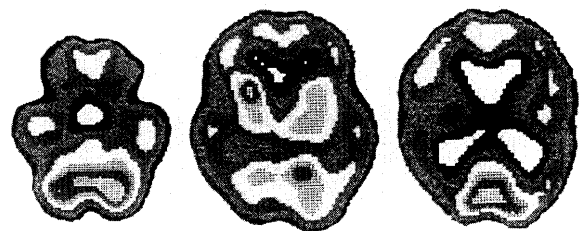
^{99m}Tc -HMPAO SPECT on day 25 revealed areas of hypoperfusion throughout the whole brain except the cerebellum and occipital lobe.
